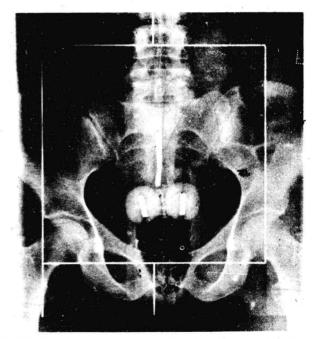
Treatment of carcinoma of the uterine cervix by insertion of radioisotope tubes into the cervical canal and the lateral fornices of the vagina, as shown on a verification X-ray film.
